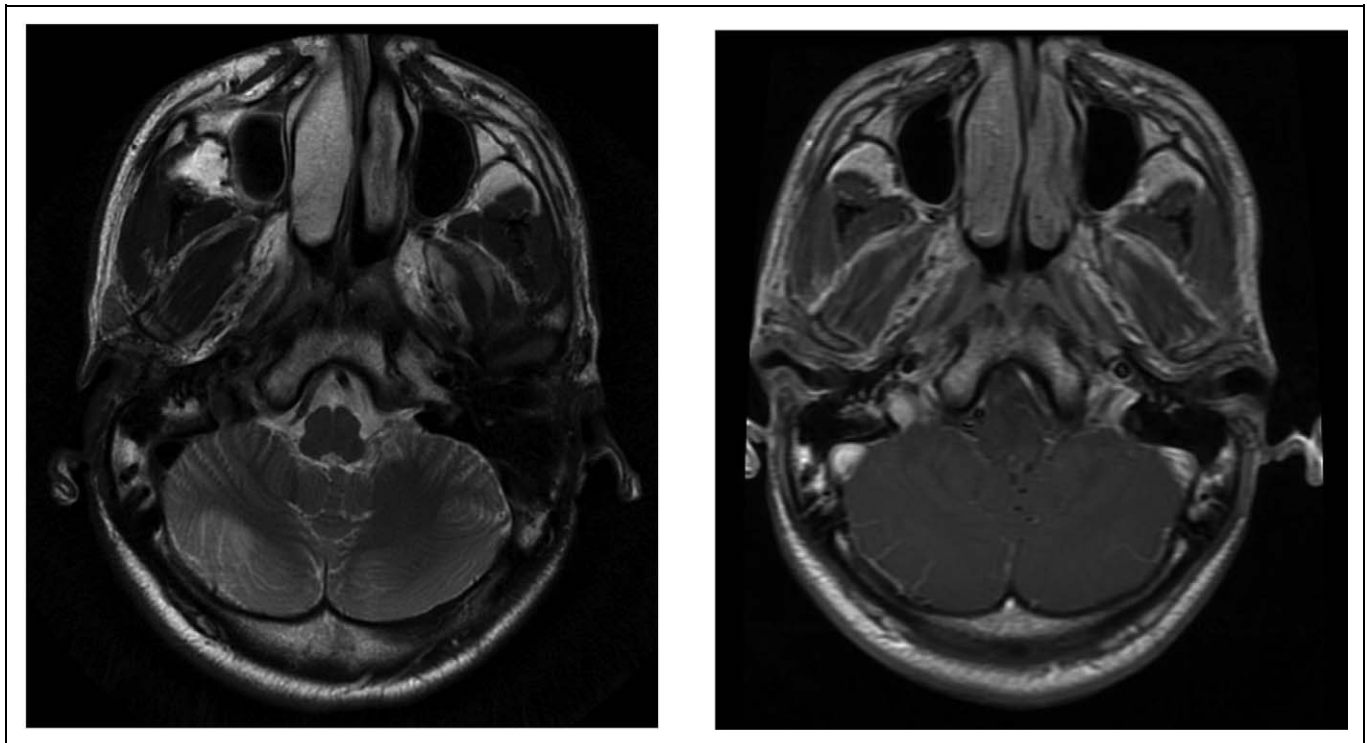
MRI scan. Left: T2 weighted (noncontrast) magnetic resonance imaging (MRI) showing an abnormal signal in the right cerebellar hemisphere correlating with the initially hyper-metabolic and later hypo-metabolic region of cerebellum. Right: T1-postcontrast MRI showing right cerebellar enhancement.
